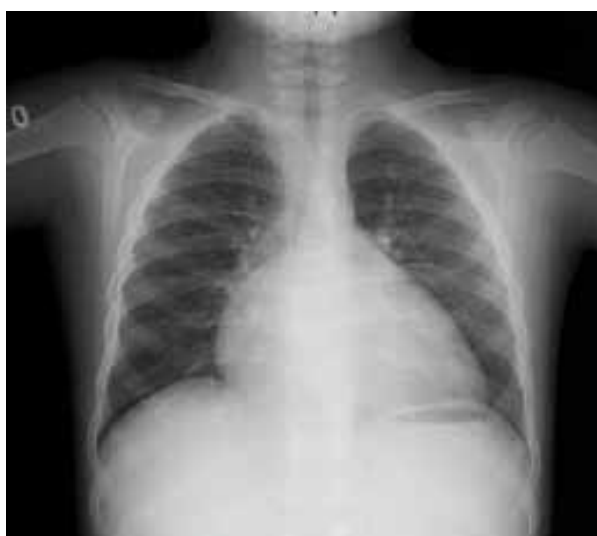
Chest X-ray after transvenous closure of atrial septal defect demonstrating cardiomegaly.
